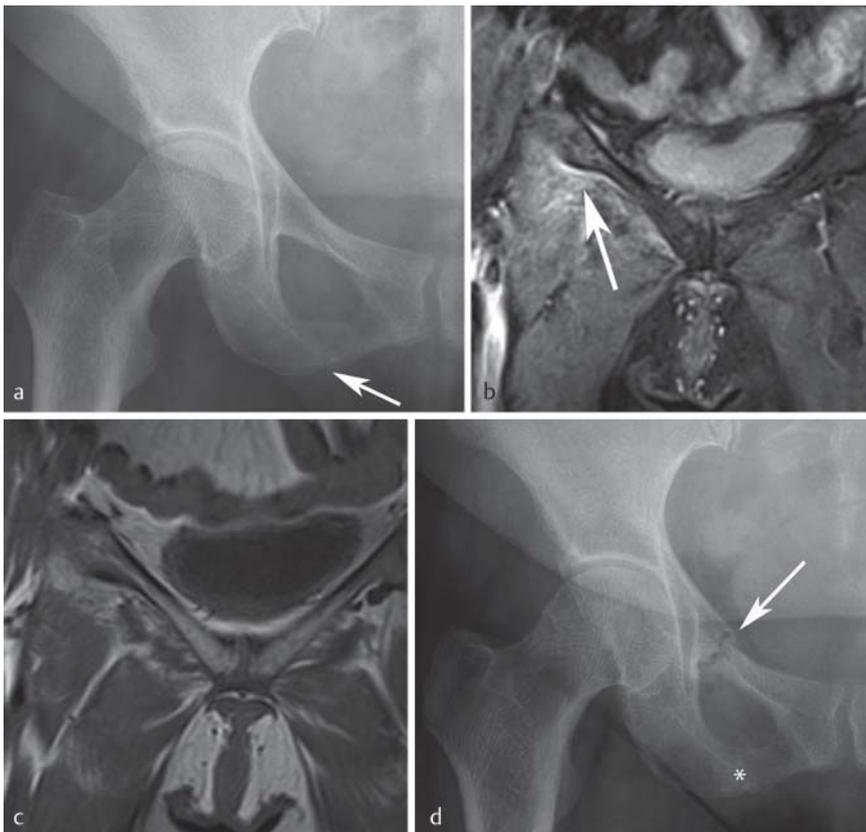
Stress fractures. The conventional X-ray image a exhibits no stress fracture on the upper pubic branch, but rather a fracture line through the lower pubic branch (arrow). The 3-Tesla MRI (b, coronal STIR; c, coronal T1-weighting) can verify the peristal accentuated osseous edema as an indication of the stress reaction of the right superior pubic ramus, and the edema of the surrounding muscles and soft tissues (arrow) (grade 3 stress fracture according to Kiuru [6]). Despite an interruption of sports activity, two months later the woman experienced a stress fracture of the upper pubic branch (arrow in d); there is callus formation around the stress fracture of the lower pubic branch (asterisk in d).
